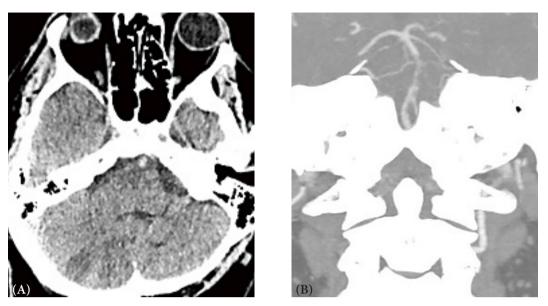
Control native CT (A) and CT angiography (B) showing reocclusion of the basilar artery and with ischemia of the cerebellum and mesencephalon.
